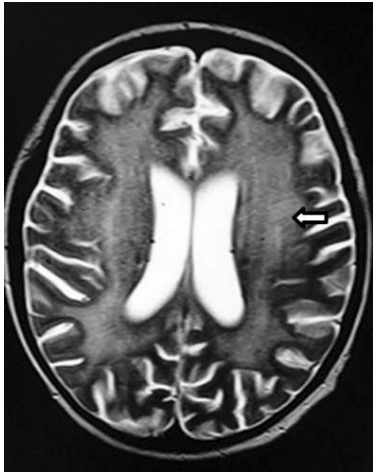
Axial T2- weighted MRI of brain showing bilateral hyperintense signals in periventricular areas (arrow).
